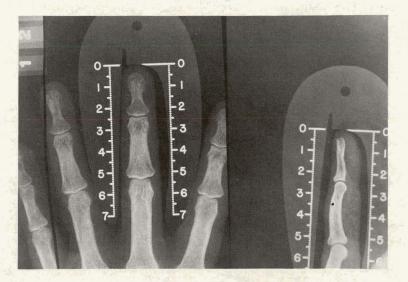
Typical radiographs of fingers with calibrated locator.
